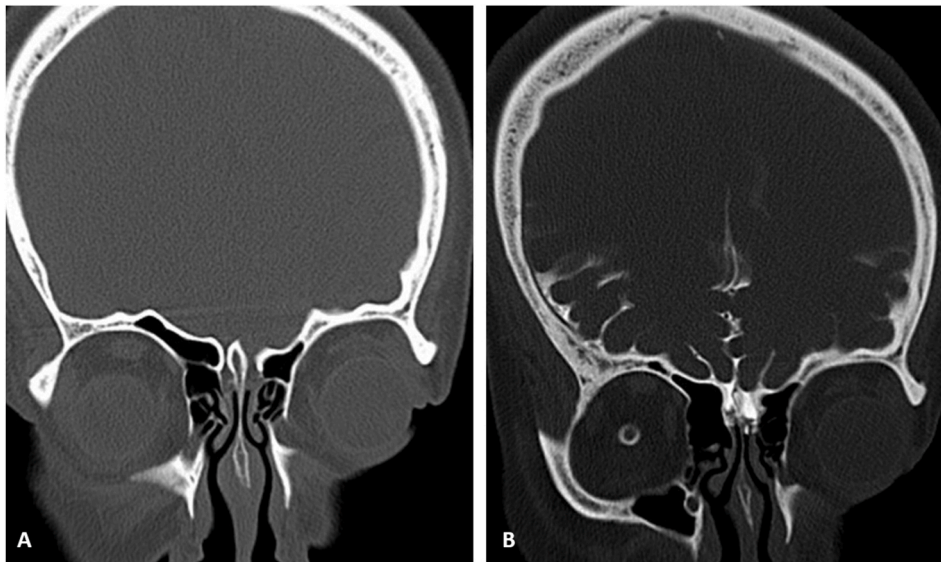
A) Non-contrast coronal CT scan showing no obvious fracture and clear paranasal sinuses B) Coronal cisternography showing CSF leakage in the right anterior ethmoidal sinus.
